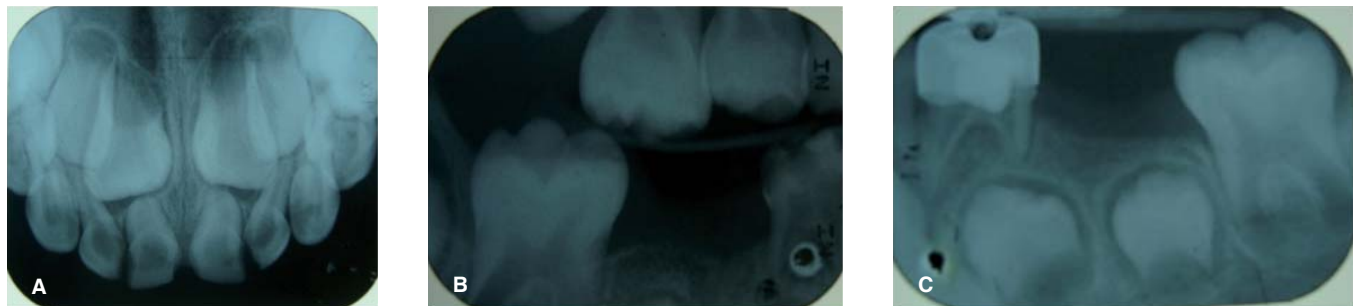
Case 1 X-rays. A) Upper occlusal X-ray, B) right bite wing X-ray, C) lower left periapical X-ray.
